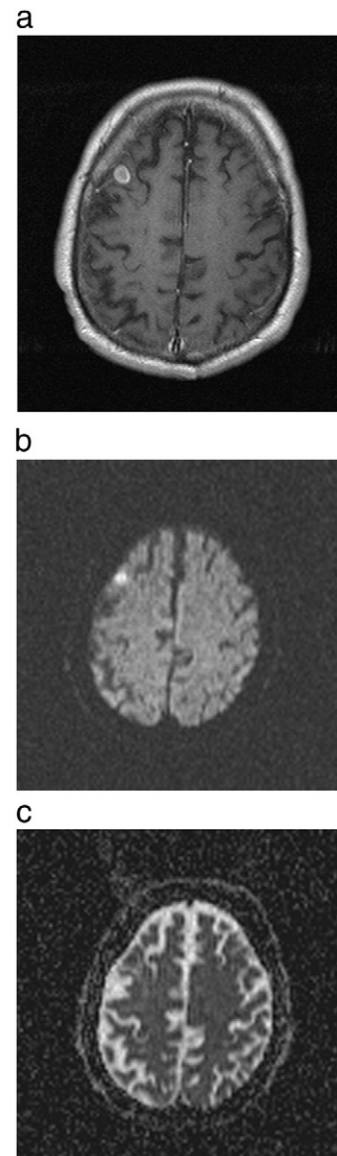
Cerebral metastasis in known small cell lung cancer. (a) T1-weighted image after intravenous administration of contrast medium showing a round lesion with homogenous enhancement in the right frontal lobe. (b) The lesion is hyperintense on b1000 image. (c) ADC map. The calculated ADC value of the metastasis is $0.53 \times 10^{-3} \text{ mm}^2\text{s}^{-1}$.
